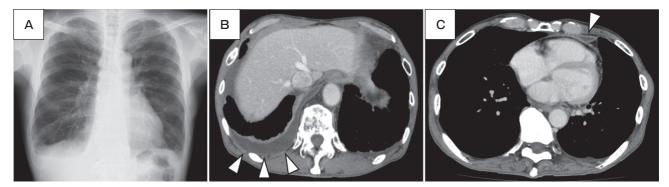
Chest X-ray (A) and CT (B, C, arrowheads) showing pleural effusions at the right-side and left-anterior thoracic cavities.
